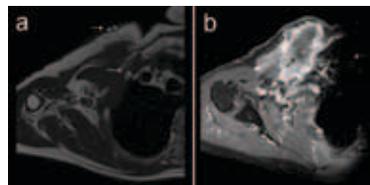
a. Transverse view of the right hemi thorax (T1 image) with markers at maximum point of pain (white arrow). Metastasis of second rib with soft-tissue components. Dashed arrow indicates targeted area for second treatment. b. CE-MRI T1 SPIR image 3 weeks post-treatment showing extensive central necrosis of soft-tissue mass (black arrow).
